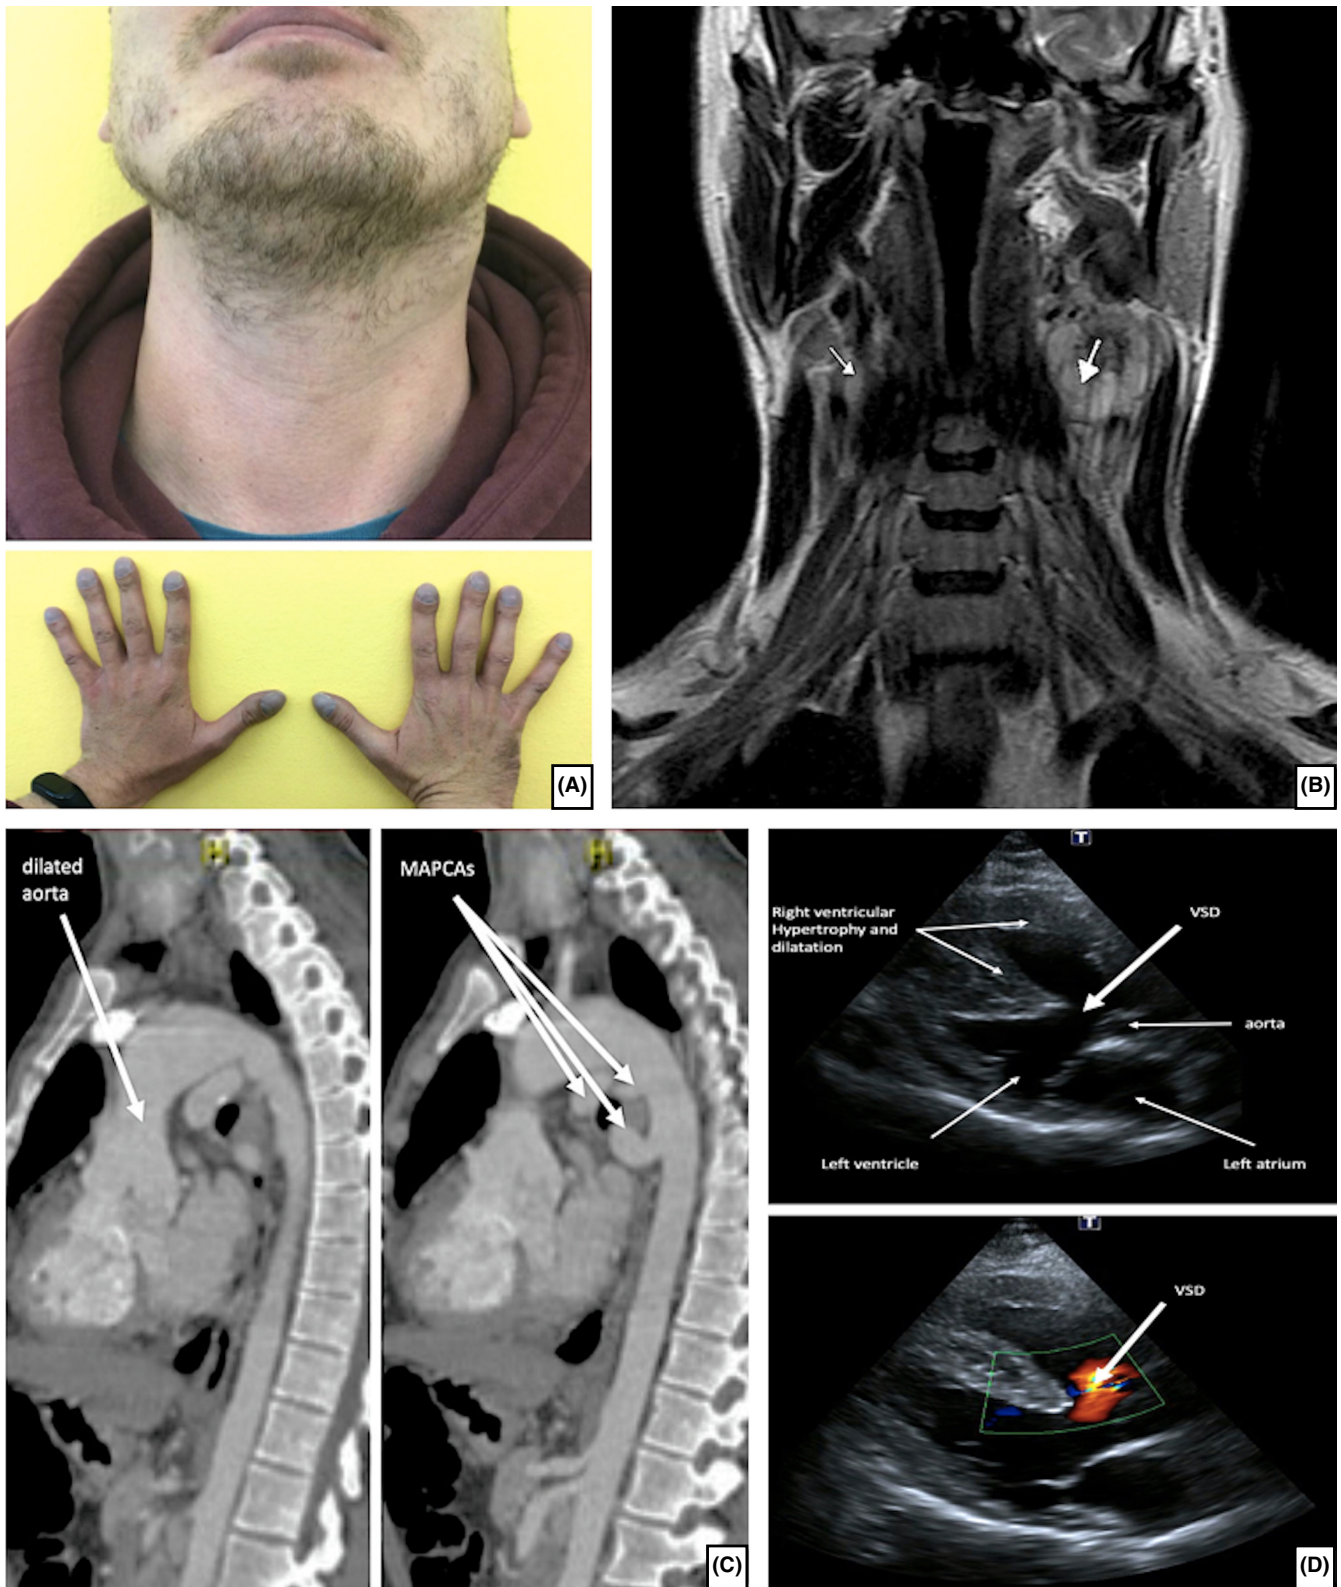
(A) Frontal view of neck (above) showing bilateral neck mass and dorsal view of hands (below) with finger clubbing. (B) Coronal T2W MRI of the neck demonstrating bilateral CBTs (arrows). (C) Lateral CT Angiography of the chest demonstrating TOF with dilated aorta and MAPCAs. (D) Parasternal long axis view from a 2D ECHO (above) with color flow doppler (below) demonstrating intracardiac defects associated with TOF.
